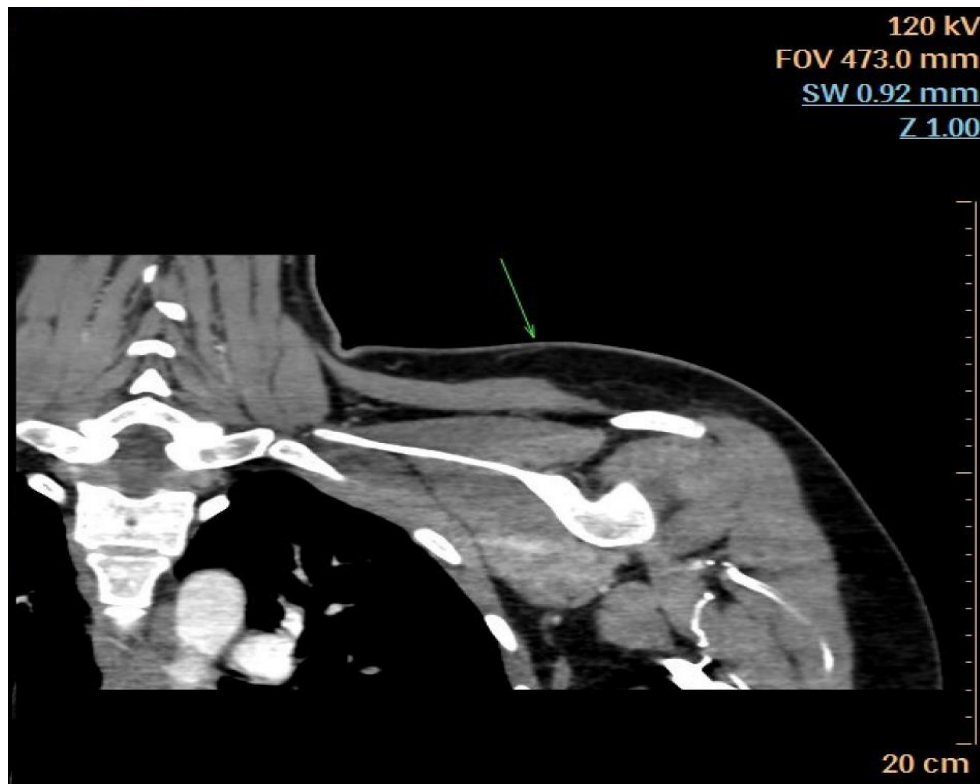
a: Computerized Tomography Angiogram (CTA) showed the site of supraclavicular artery perforator to the skin (the arrow).
